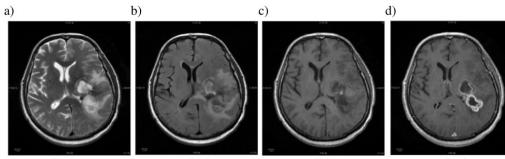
This is an ELMED219 dummy figure. (a) T2w, (b) FLAIR, (c) T1w, (d) T1wGd. (Image taken from study TCGA-06-1802 in the TCGA-GBM data collection [ref [1] in Section 2])
